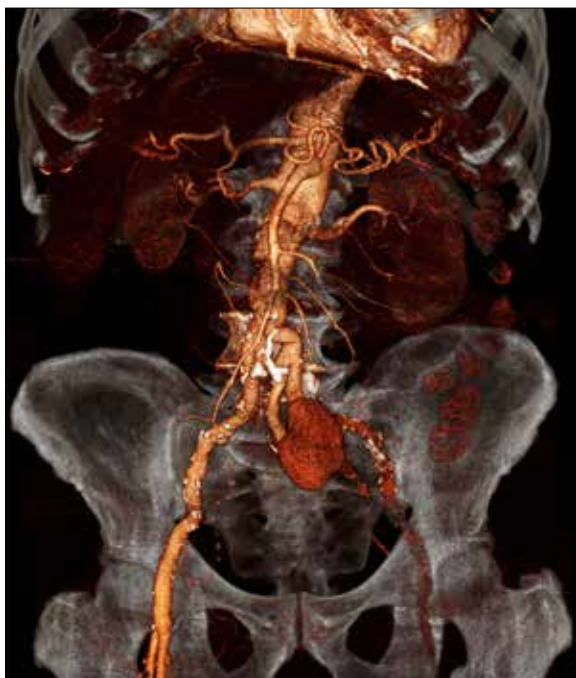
CT-Angiography image (shaded surface rendering) showing a large false aneurysm involving both the left iliac branches which are less opacified due to contrast media leakage into the sac. The CT-A also demonstrates kinking of the vessels upstream of the pseudoaneurysm.
